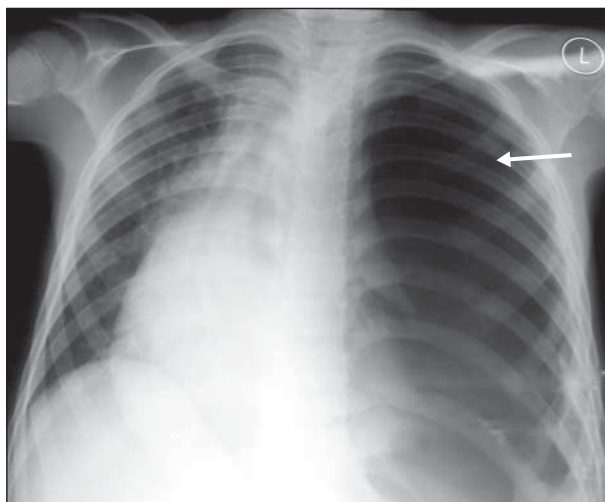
Chest radiography was repeated following the development of acute respiratory distress and revealed a tension pneumothorax (arrow pointing at an absence of lung markings on the left side of the chest). L indicates left.
